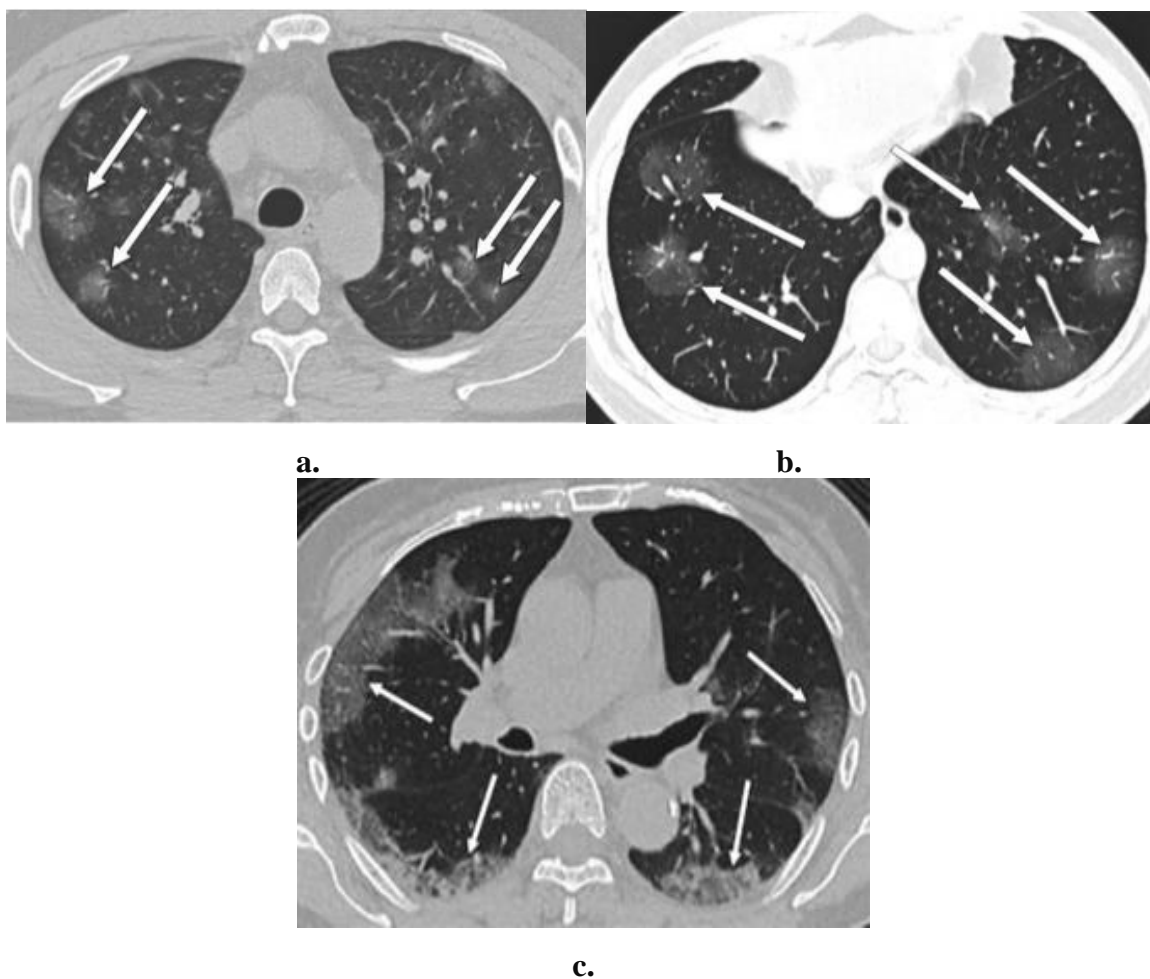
(a): Axial CT scan image obtained without intravenous contrast material of a 36-year-old male patient shows ground-glass opacities in upper lobes with round morphology (arrows). (b) Axial CT scan image of a 44-year-old male patient with round morphology (arrows). (c) Axial CT scan image of 65-year-old female patient shows bilateral ground-glass and consolidative with a striking peripheral distribution (arrows).^[48]
